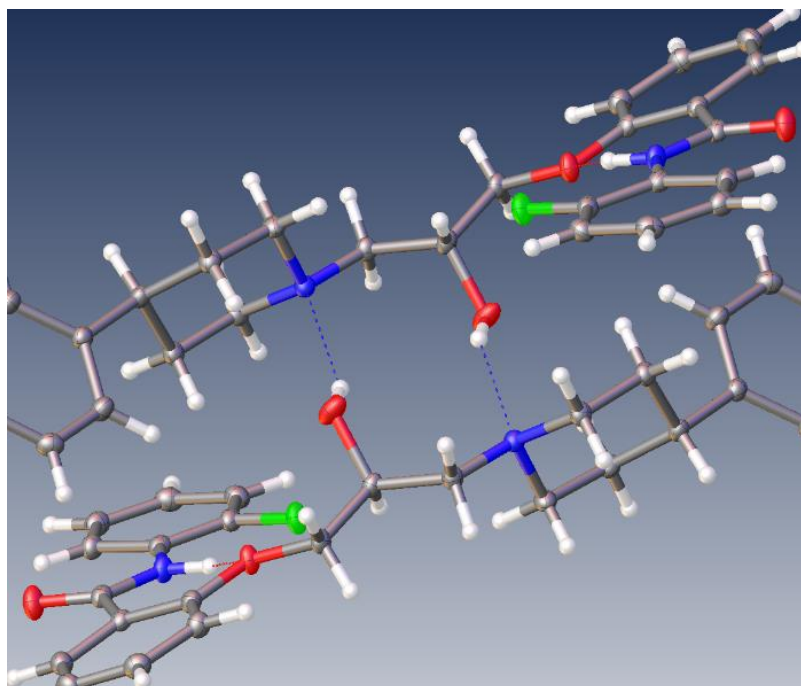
X-ray structure of 184 (dimer).
